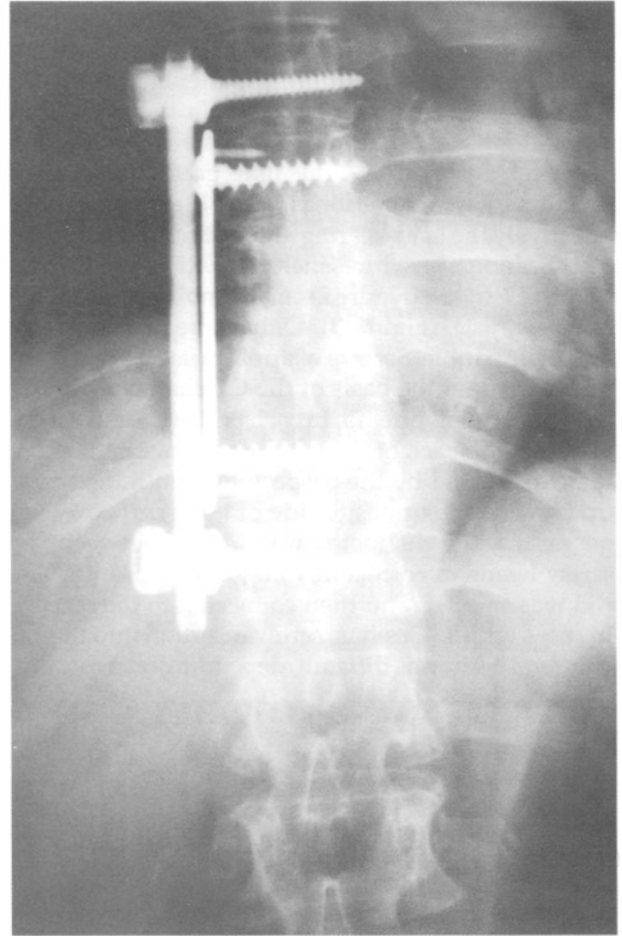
Anteroposterior radiograph 32 months after surgery. Following resection of two vertebral bodies, a combined SRF and SPF procedure was performed.
